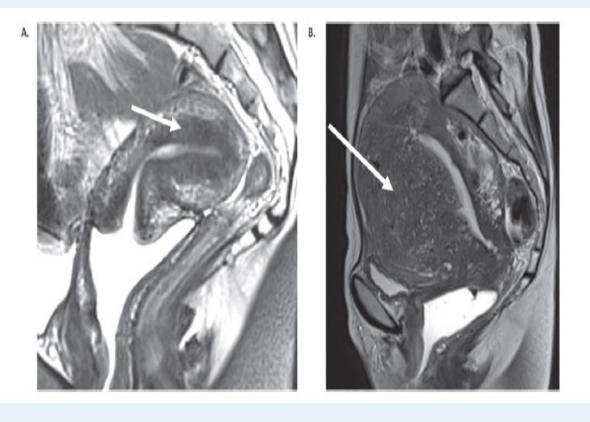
MRI sagittal T2-weighted images of adenomyosis. (A) Thickening of the junctional zone (JZ) (white arrow). Ratio of JZ maximum/total myometrium over 40%. (B) Severe adenomyosis of the anterior uterine wall (white arrow), with intramyometrial cysts (hyperechoic in T2 sequences).
